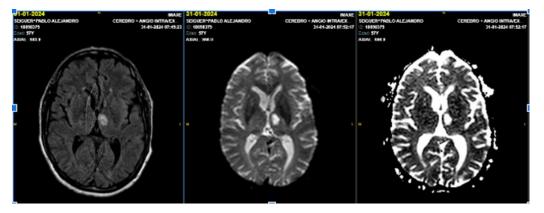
Brain MRI (Flair, DWI, ADC) subacute ischemic lesion is evident in the left thalamus.
